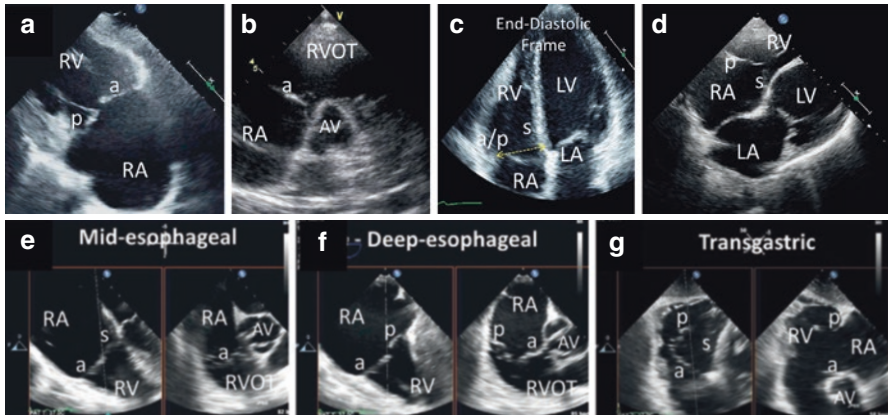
Transthoracic and transesophageal imaging planes for the TV. Multiple transthoracic imaging planes (a–d) should be performed for comprehensive imaging of the tricuspid valve (TV). The parasternal inflow view (a) images the anterior (a) and posterior (p) leaflets when no ventricular septum is in the imaging plane. (b) Parasternal short-axis view at the level of the aortic valve; when the transducer is angled anteriorly, only the anterior (a) leaflet is seen (with no other leaflet coaptation). (c) On-axis 4-chamber view with the left ventricle (LV) in the apex of the sector. The end-diastolic frame shown should be used to measure the annular diameter (*dashed yellow double arrow*). A subcostal view is shown in d. Transesophageal imaging planes (e–g) should be performed from multiple levels. These examples from the mid-esophageal view (e), the deep-esophageal view (f), and the transgastric view (g) are simultaneous multiplane images showing the primary imaging plane on the left of each panel, and the orthogonal (rotated 90°) image on the right side of each panel. AV ¼ aortic valve; LA ¼ left atrium; RA ¼ right atrium; RV ¼ right ventricle; RVOT ¼ right ventricular outflow tract; s ¼ septal leaflet
